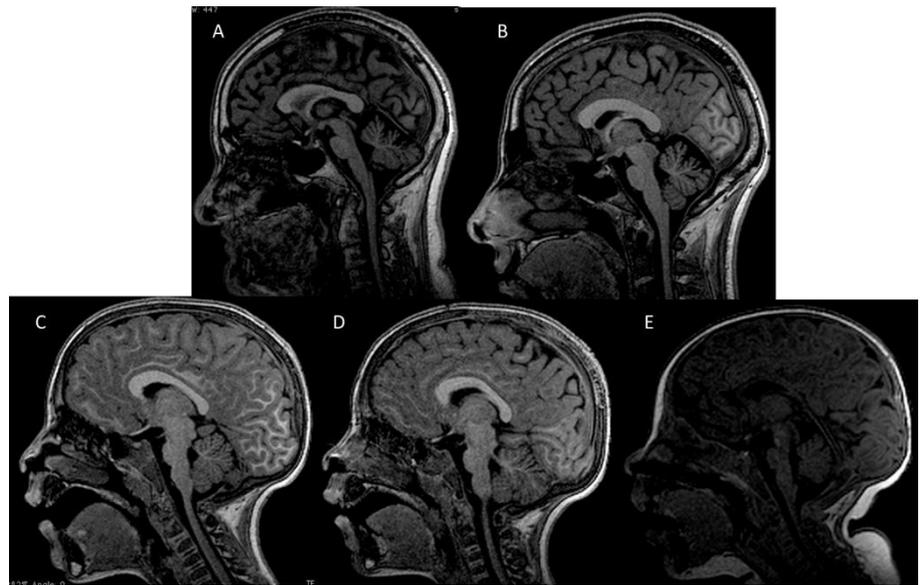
MRI brain scans T1 weight of grandmother (A), mother (B), daughters (C, D, E)
